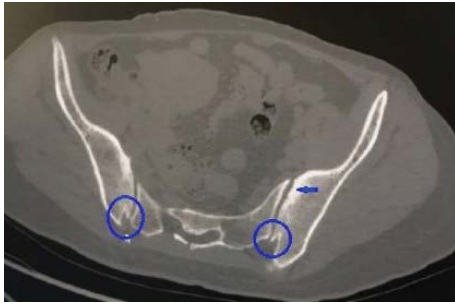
Axial computed tomography section image of the bilateral bipartite iliac bony plate variation (circled) at the S3 vertebral level in a 33-year-old woman patient. The blue arrow indicates subchondral sclerosis at the S1 vertebral level.
